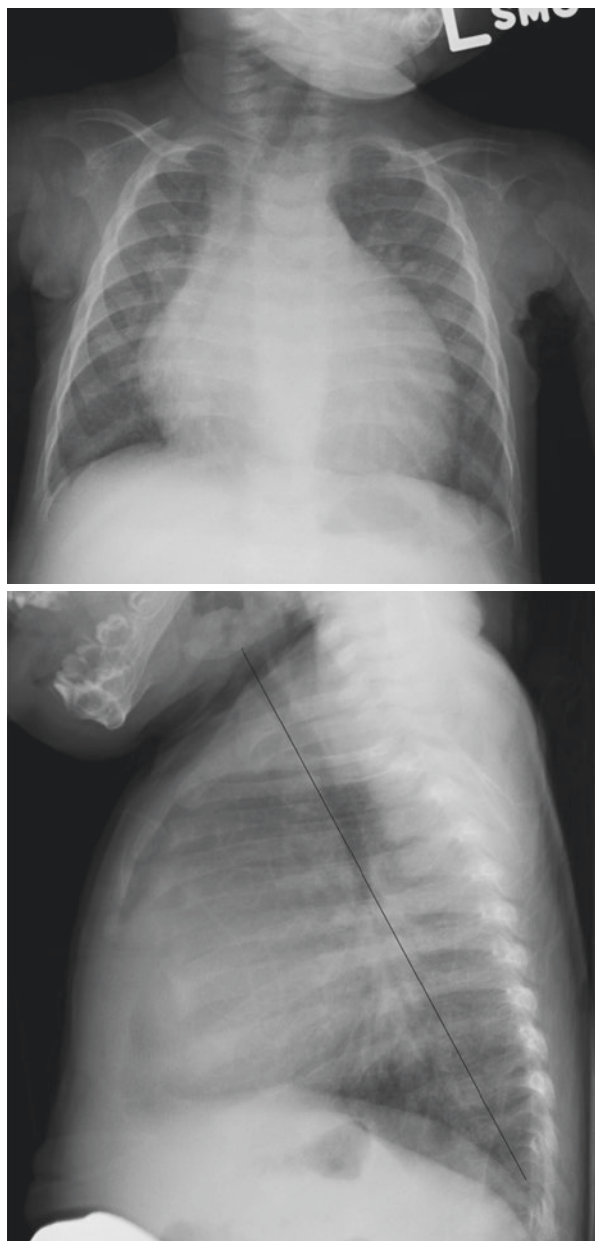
A 3-month-old female who presented with tachypnea. Chest radiograph shows a large cardiac silhouette on the frontal and lateral views and pulmonary venous congestion. The anterior tracheal line (drawn on the lateral view) intersects the spine above the diaphragm on the lateral view. Genetics evaluation yielded a diagnosis of Pompe disease
